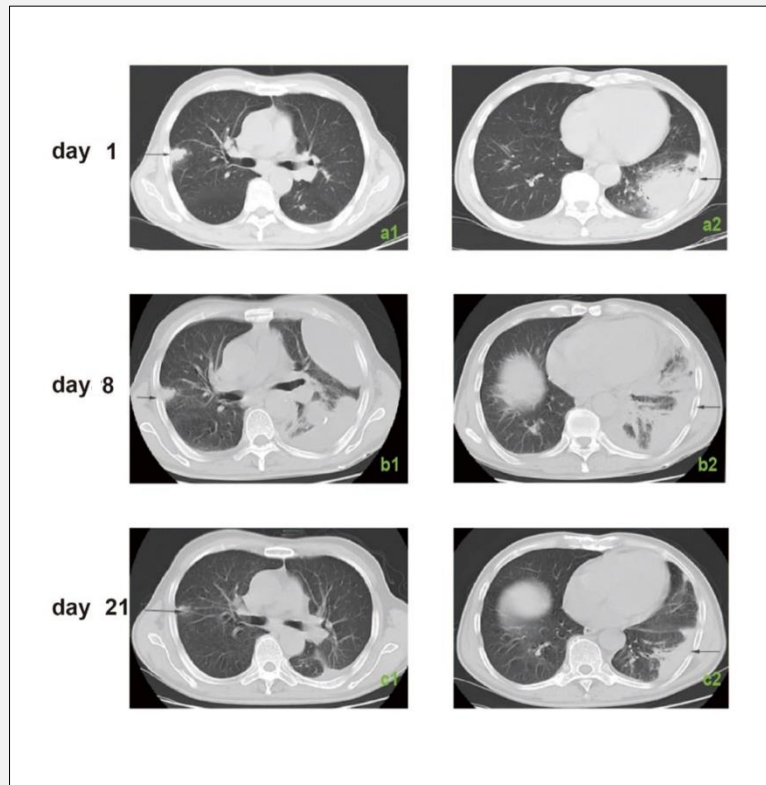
Chest-CT on day 1, day 8, and day 21.
